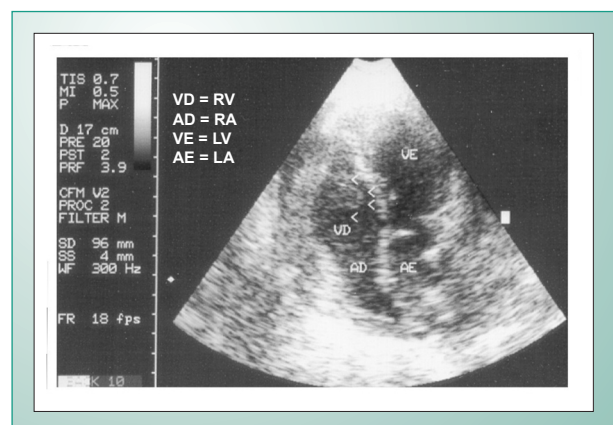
Echocardiogram showing mass with protrusion into the right ventricle cavity (apical incidence four chambers transthoracic).
